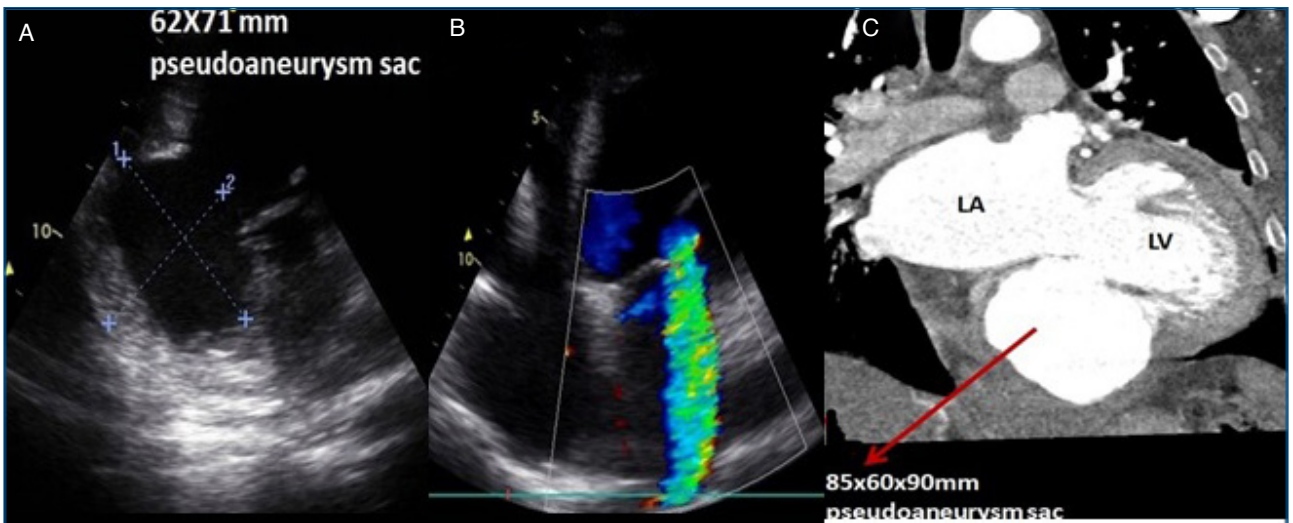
(A, B) Echocardiographic image of pseudoaneurysm sac and thrombus formation and distorted mitral valve posteromedial papillary muscle and eccentric severe mitral regurgitation. (C) Cardiac computed tomography angiographic image of the 85 × 60 × 90 mm pseudoaneurysm sac.
